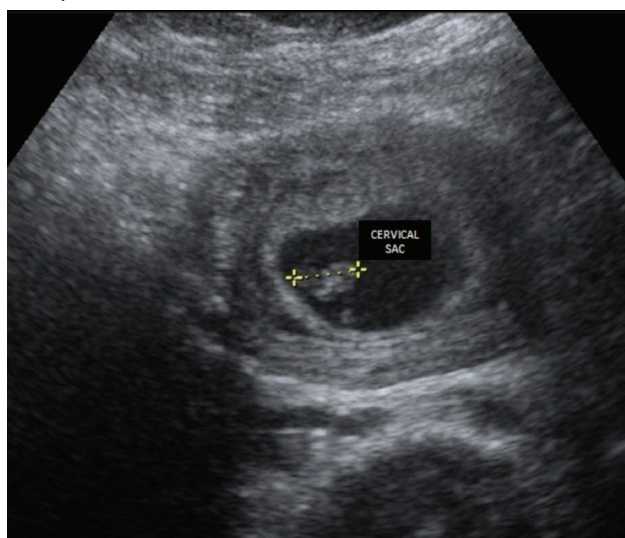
Transvaginal two-dimensional ultrasonography showing uterine and cervical sac
